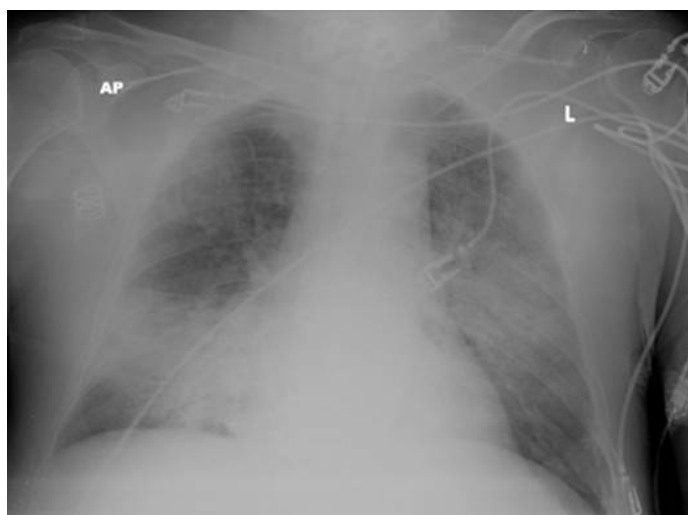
Chest x-ray on admission showing bilateral interstitial infiltrates, especially in the right lower lung field.
